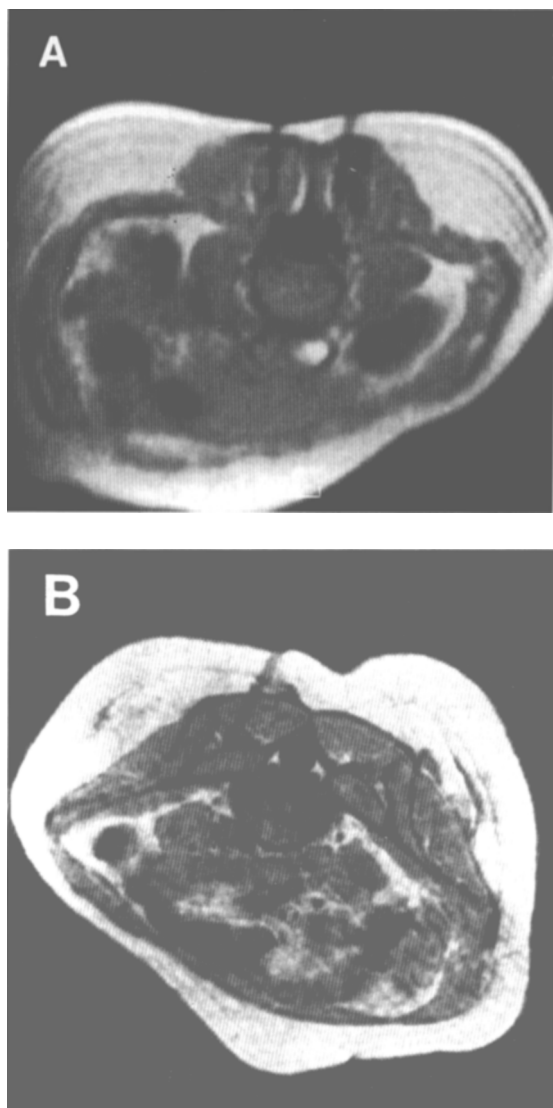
MRI-scopic treatment for low back pain (low risk area [LoRA]). (A) facet joints and (B) ilio-sacral joints.
